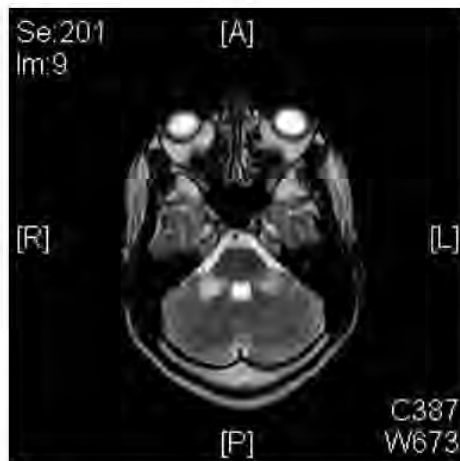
T2-weighted magnetic resonance image demonstrating the high signal intensity, well-circumscribed lesions in the cerebellar peduncles
